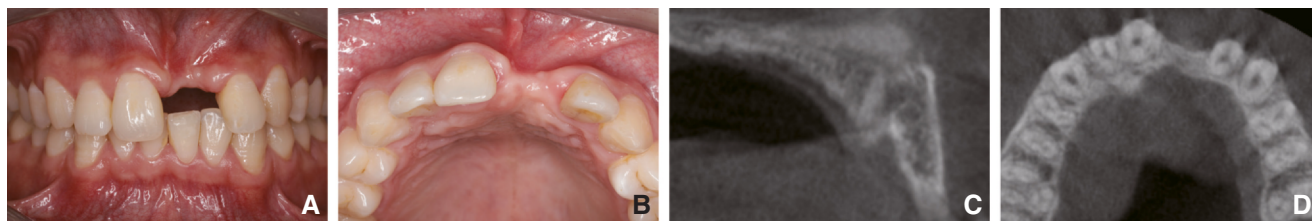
Pretreatment examination. A, Frontal view. B, Occlusal view. C, D, Cone beam computed tomography images indicating severe horizontal ridge deficiency.
